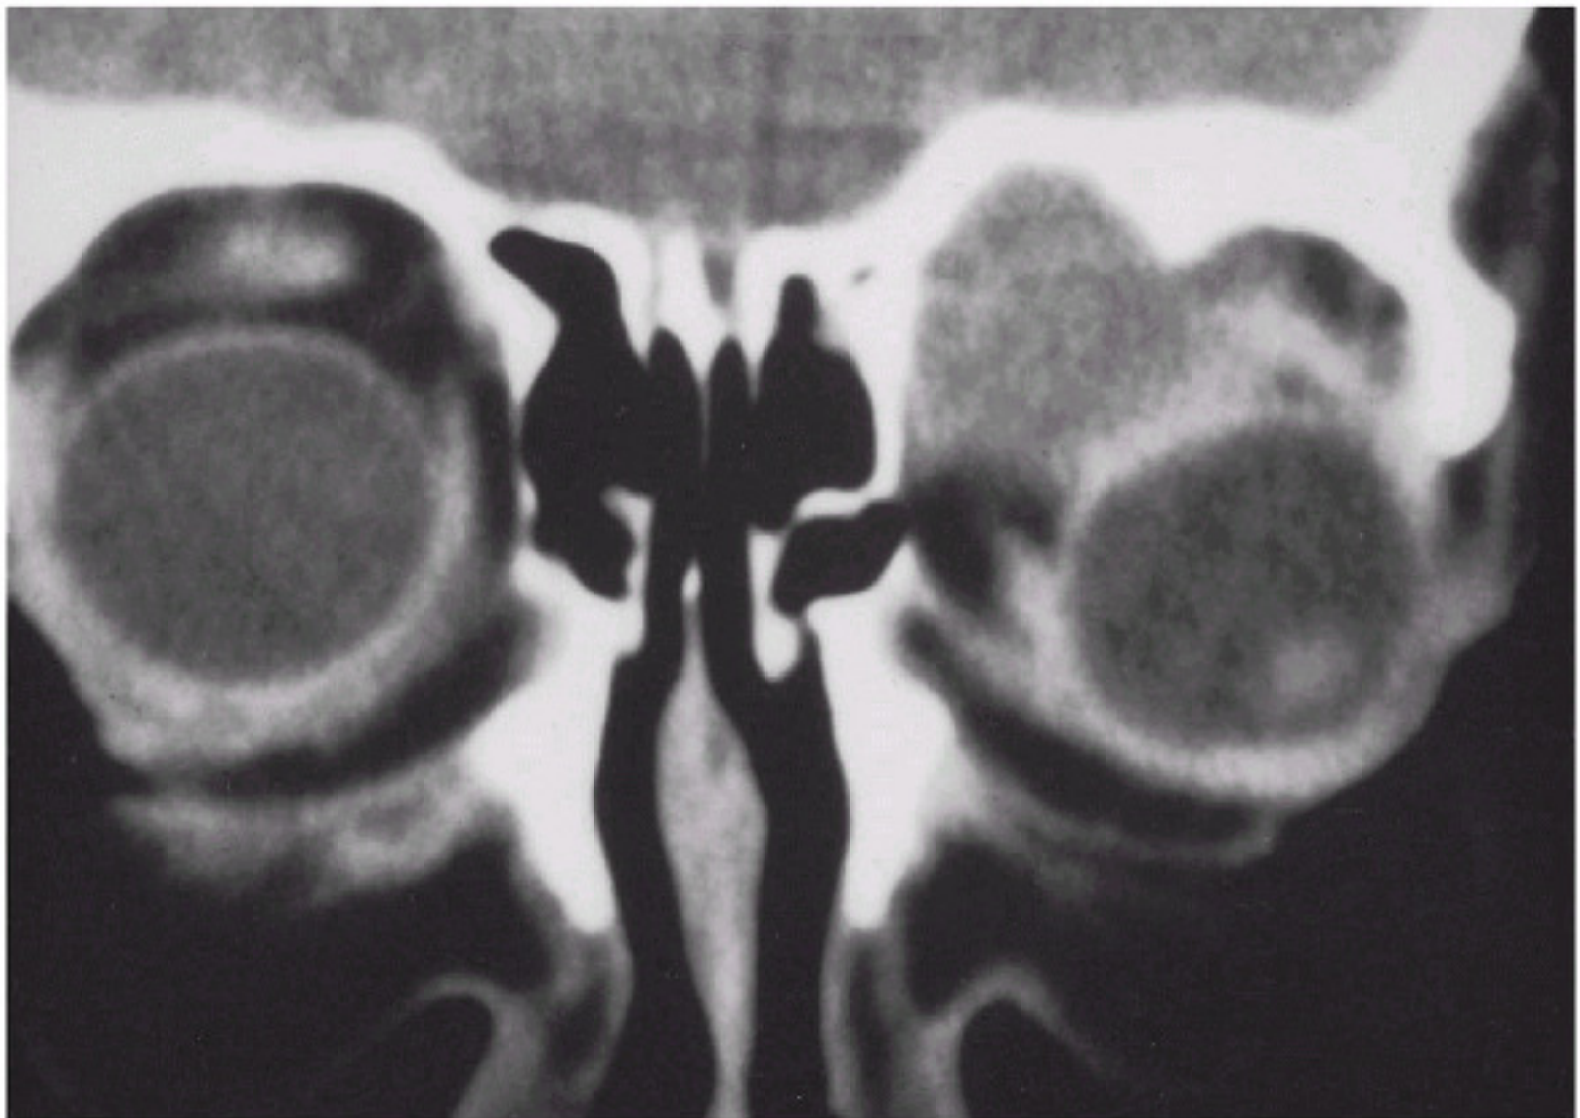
Coronal computed tomography scan demonstrating a superior subperiosteal abscess.
